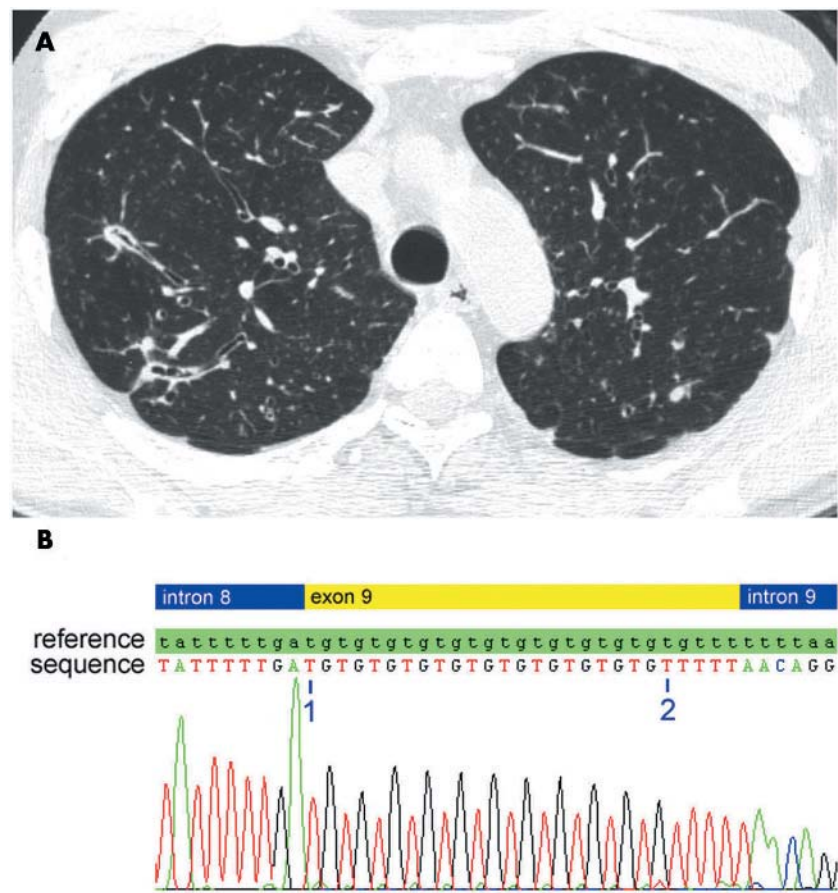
(A) Chest CT scan showing bronchiectasis and bronchial wall thickening predominating in the right upper lobes. (B) Sequencing of the IVS8 locus. 1 indicates the first T of the 11 TG repeats and 2 shows the first T of the 5T motif of the IVS8 locus. The reference DNA sequence is indicated as "reference" and the DNA sequence of the patient is indicated as "sequence".
